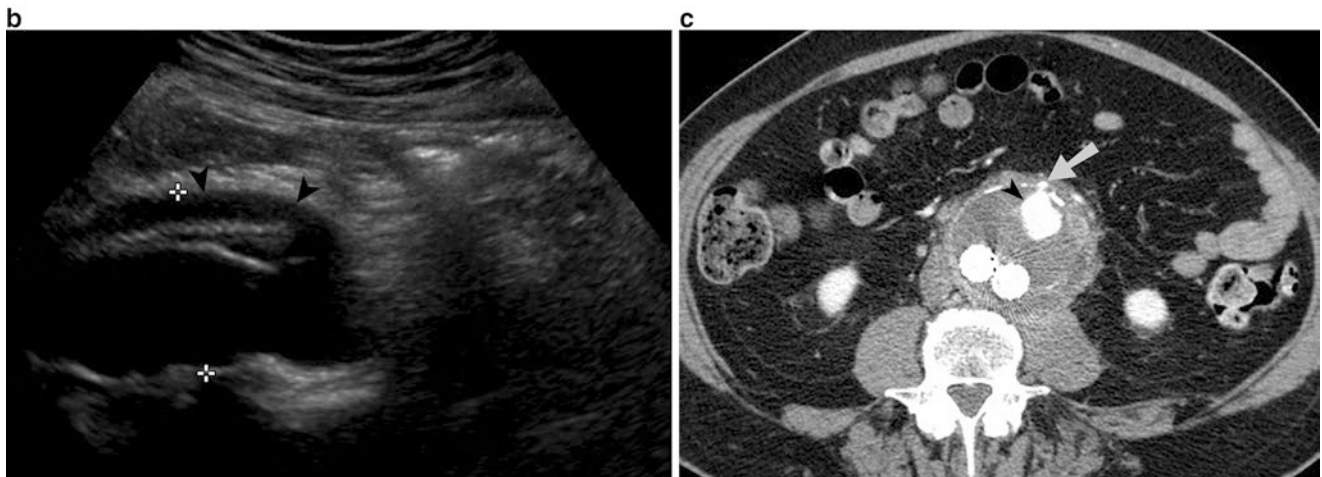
Intramural hematoma. (a) Contrast-enhanced CT demonstrates asymmetric aortic wall thickening, consistent with intramural hematoma (arrowheads) in the descending thoracic aorta. (b)
